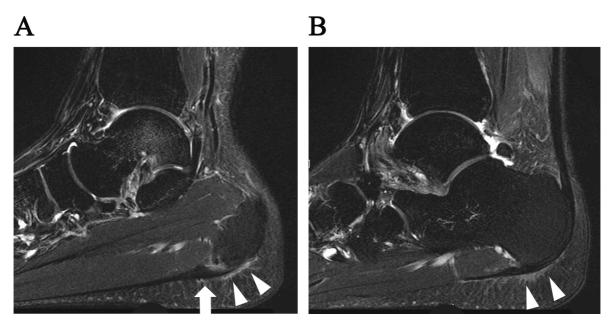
T2-weighted fat-saturated images just before the second corticosteroid injection shows (A) hyperplasia of the plantar fascia insertion (arrow) and (A, B) a high-intensity zone in the fat pad below the plantar fascia (arrowhead).
